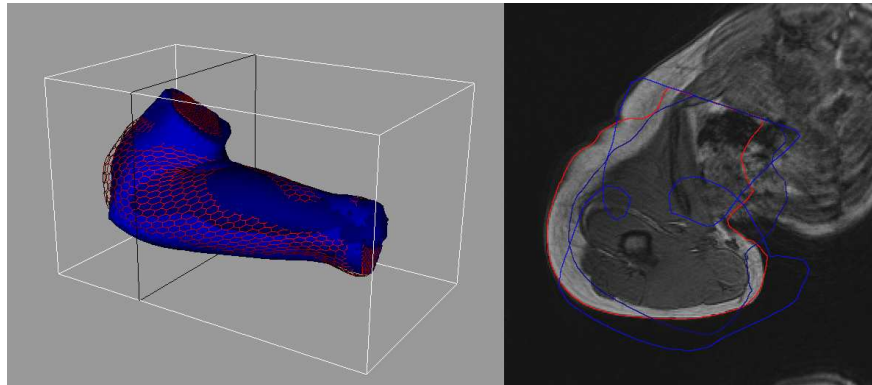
Skin tracking from sequential MRI (extreme posture): fitted surface (red), intra-patient initialisation (blue) and inter-patient initialisation (dark blue)
